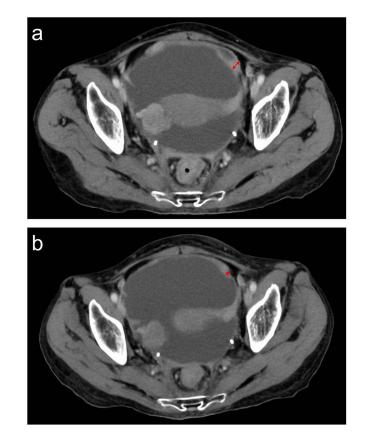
Figure I Abdominal contrast-enhanced computed tomography showing ascites and peritoneal metastasis ( $\leftrightarrow$  thickness of peritoneal metastasis) (a) on admission (12.8mm) and (b) 20 days after administration of CPT-II and ramucirumab (7.9mm).
